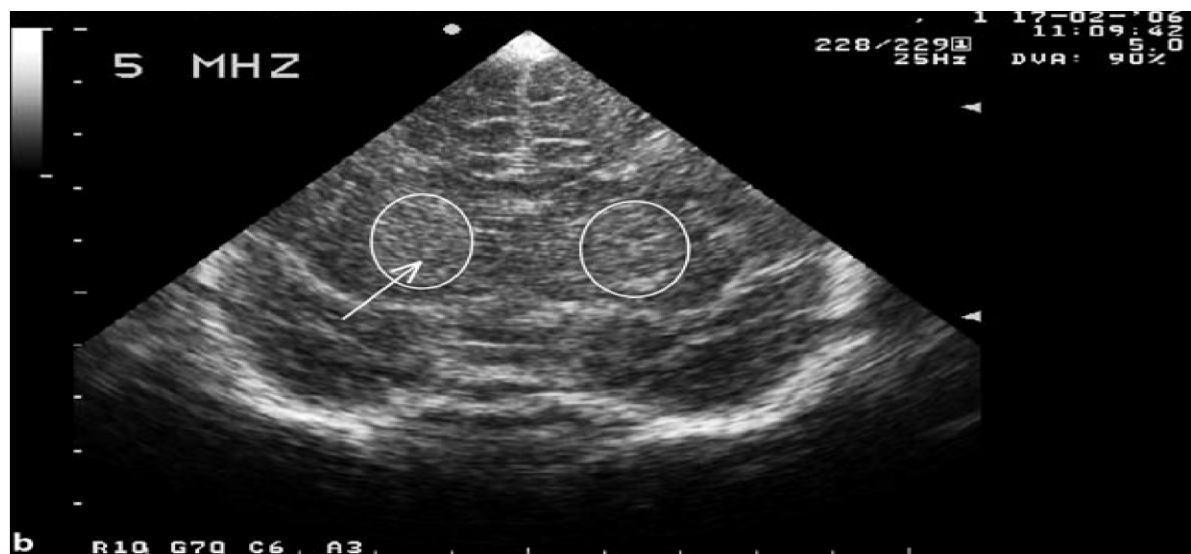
a Coronal ultrasound scan in a full-term baby, born asphyxiated, at the level of the frontal horns of the lateral ventricles. Transducer frequency of 7.5 MHz. b Coronal ultrasound scan in the same baby after decreasing the transducer frequency down to 5 MHz, now showing more clearly the subtly increased echogenicity of the basal ganglia (arrow). Basal ganglia injury became more obvious during the following days
